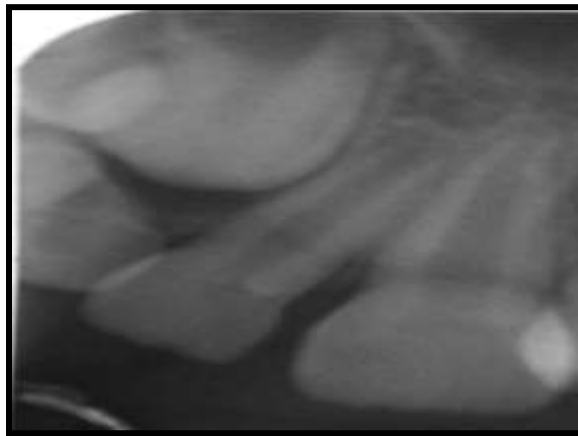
Radiograph revealing a calcified mass between premolars.
